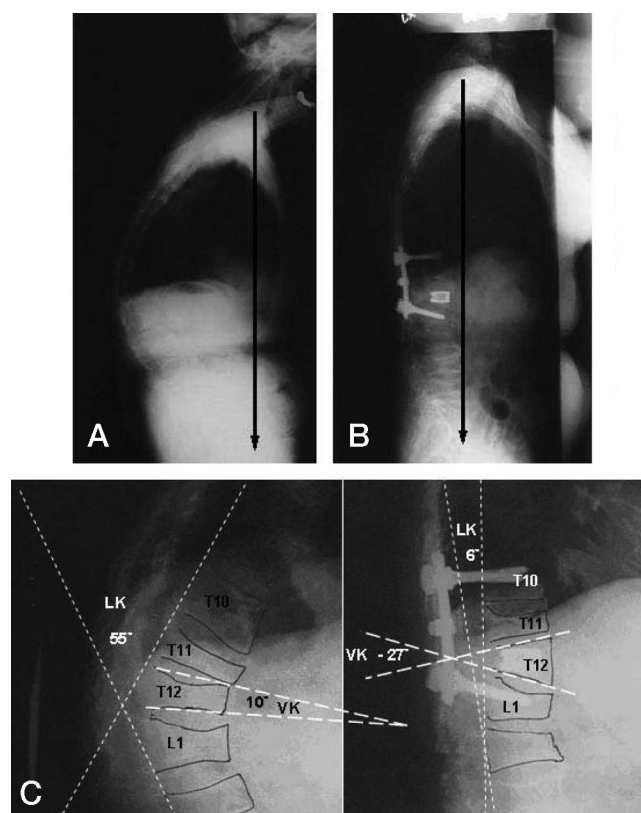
A, This 73-year-old man presented with a progressive and painful junctional thoracolumbar kyphosis as a result of wedge fractures at T11, T12, and L1. B, Standing radiographs obtained at 2 years postoperatively showed a normal thoracolumbar junction and good balance. C, The local kyphosis (LK) was corrected from 55° to 6°. The vertebral kyphosis (VK) was corrected from 10° to -27°.
